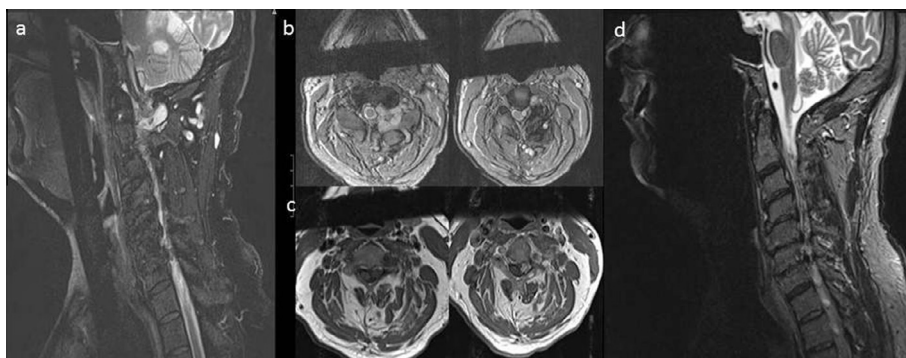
(a) Sagittal fat-suppressed short T1 inversion recovery MRI of the cervical spine showing a lobulated soft tissue mass arising adjacent to C2–3, compressing the thecal sac and spinal cord on the left as seen on (b) axial gradient echo and (c) axial T1-weighted sequences. (d) Sagittal fat-suppressed short T1 inversion recovery MRI of the cervical spine post coil and Onyx embolization (ev3 Endovascular, Plymouth, MA, USA) showing obliteration of the vascular mass.
